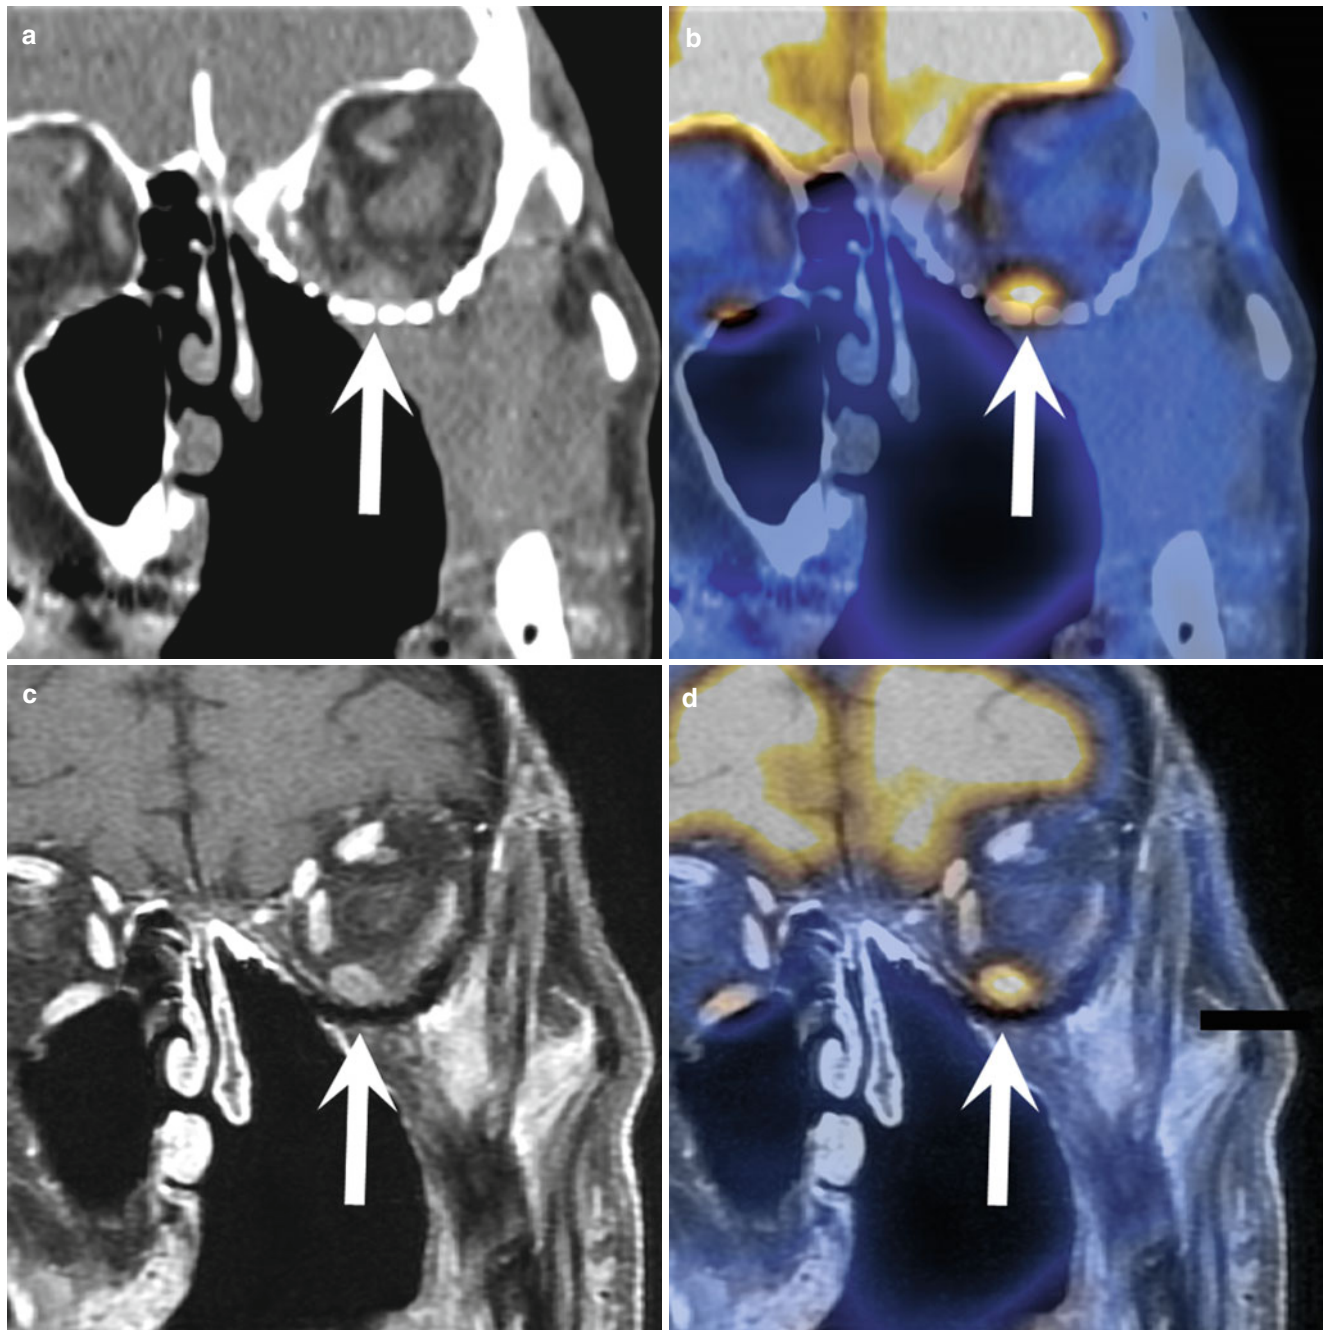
Follow-up imaging after radiotherapy and reconstruction of the floor of the left orbit, which was infiltrated by a maxillary sinus carcinoma. An FDG-avid mass is seen in the orbit right above the reconstructed floor with surrounding stranding of the intraconal and extraconal adipose tissue on coronal CT image (a, *arrow*) and coronal
